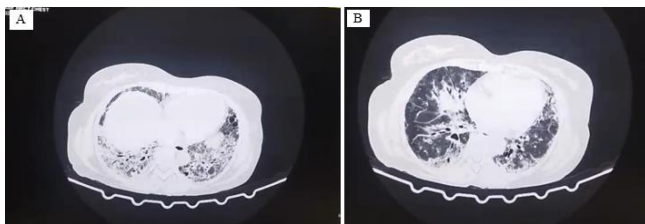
A,B: HRCT Chest: Evidence of extensive honeycombing with traction bronchiectasis with patchy areas of consolidation
